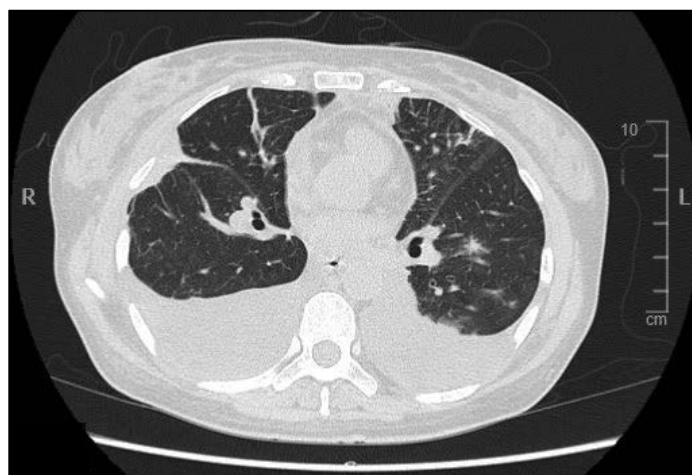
Chest computed tomography on ICU day -3. Bilateral pleural effusions, right predominant, with mild parenchymal involvement.
